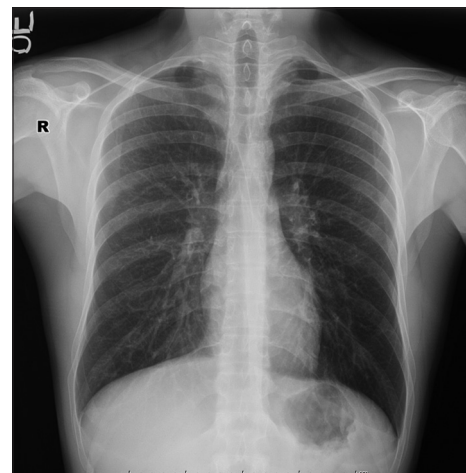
Chest X-ray of case 2. His radiography was showing ill-defined nodules with reticonodular changes predominating at the upper-middle lobes
